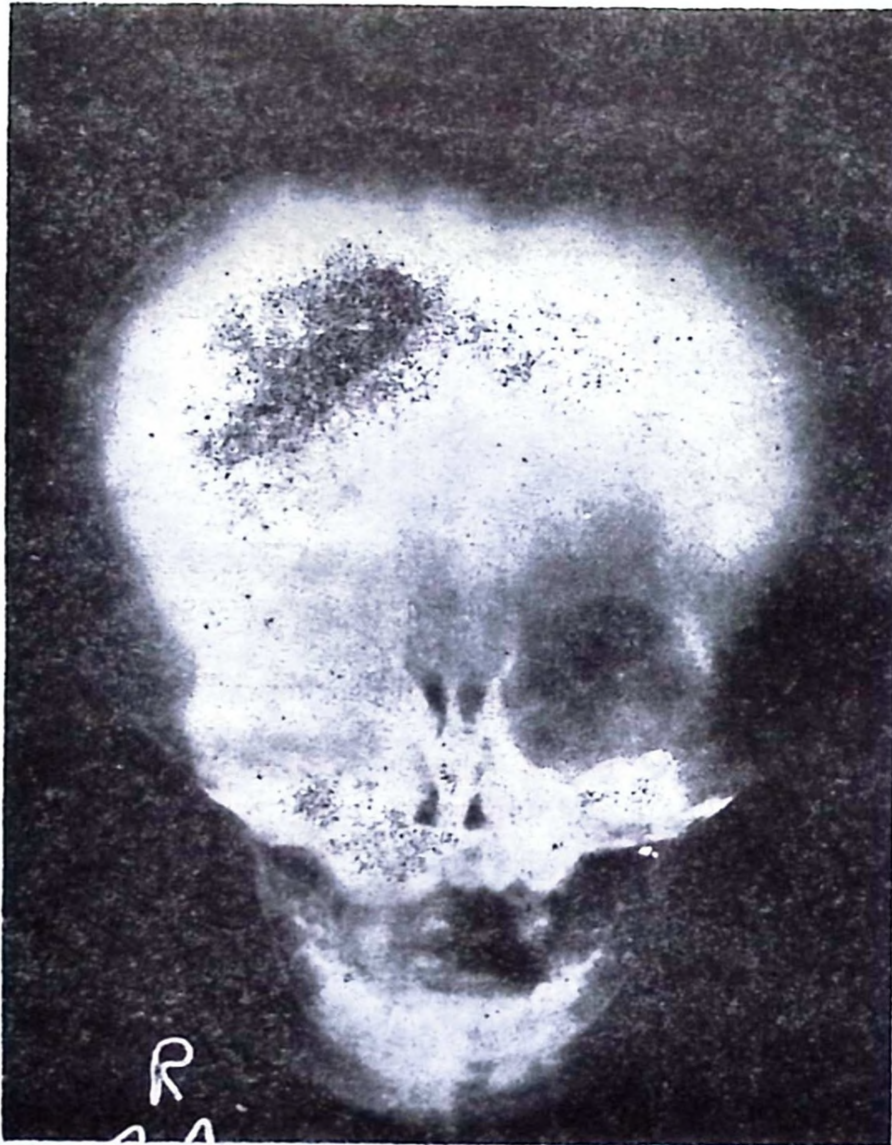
X-ray of skull after eight months of treatment, showing slight thickening of the cortex and some widening of the diploic space.
